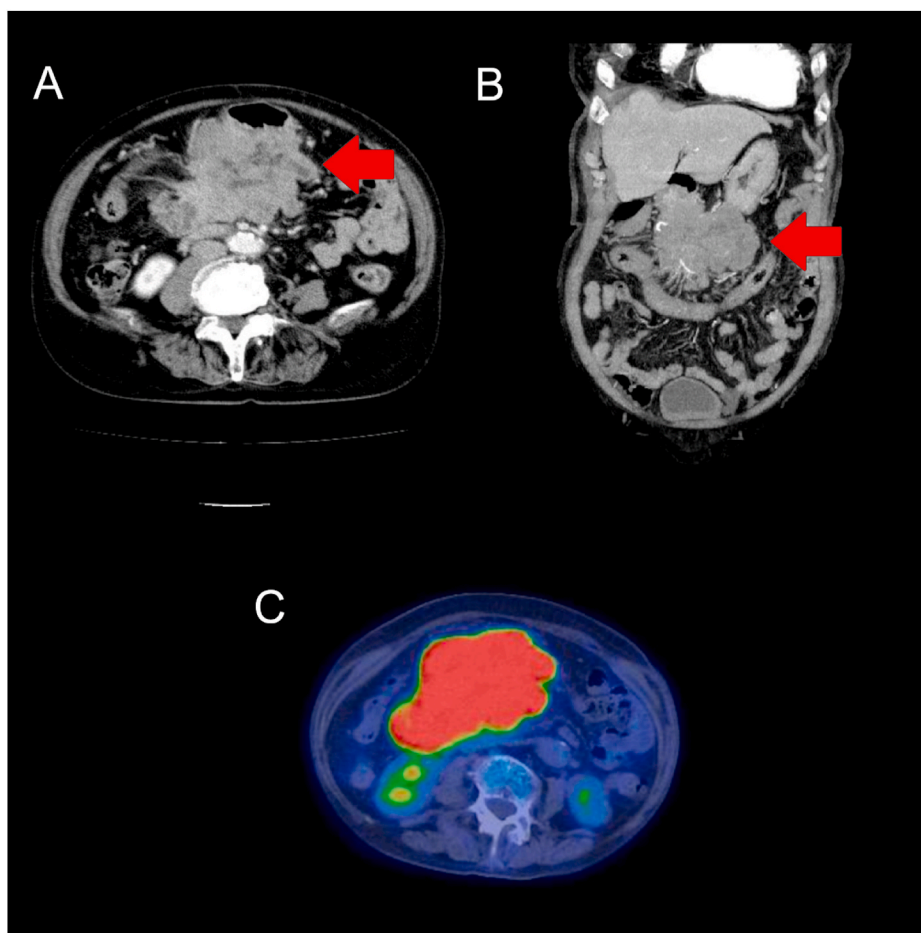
Abdominal computed tomography at the time of recurrence. A is an axial section, B is a coronal section and C is a positron emission tomography-computed tomography image. A 121 \times 71 mm large irregular mass extending caudal to the posterior wall of the lower stomach was seen (arrow).
